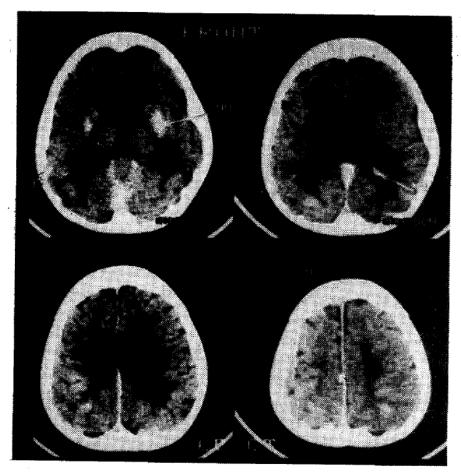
Contrast enhanced CT scan shows moderate hydrocephalus and basal ganglionic calcification.
